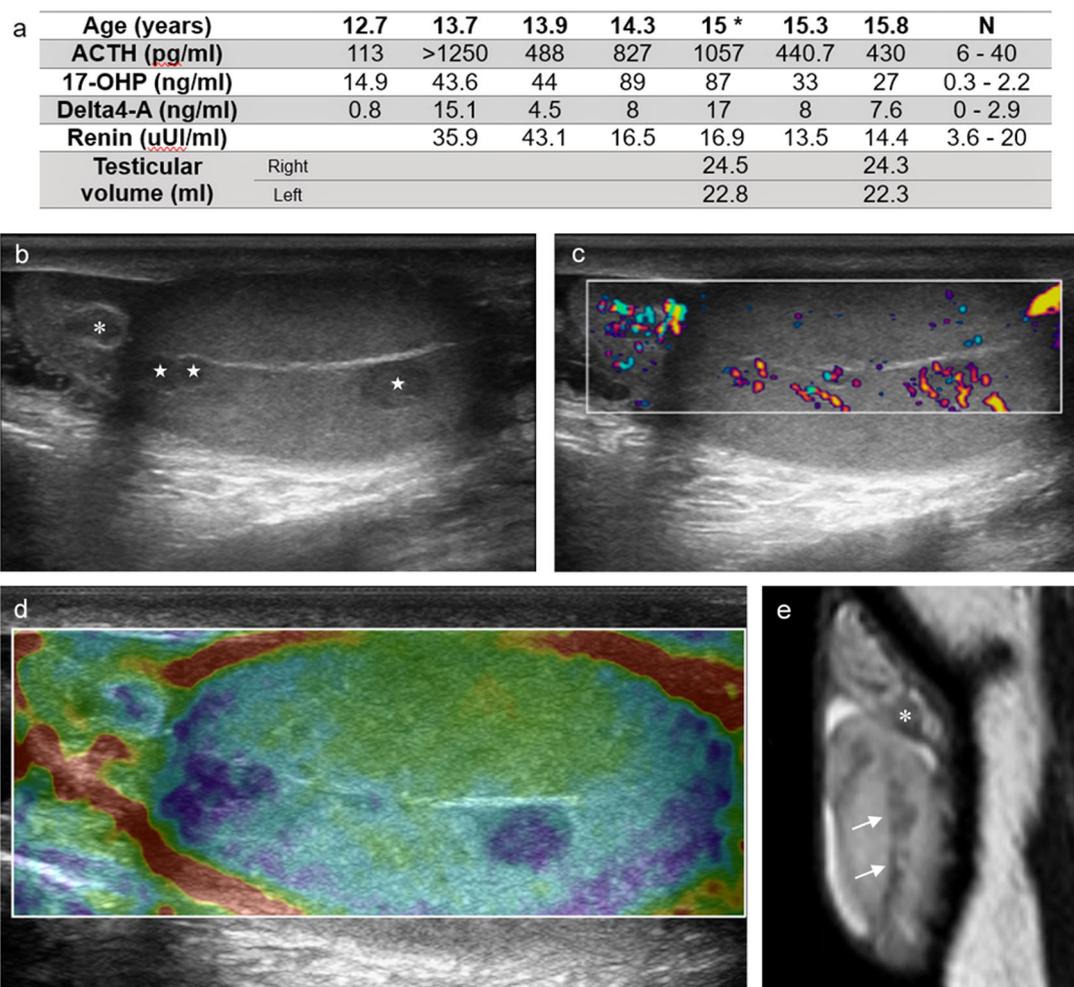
a follow-up of laboratory tests and testicular volume at ultrasound [TART diagnosis (*), normal hormonal range (N), 17-hydroxyprogesterone (17-OHP), Delta4-androstenedione (Delta4-A)]. b b-mode ultrasonography image of the right testis; c Power-Doppler ultrasonography image of the right testis; d Strain Elastography
